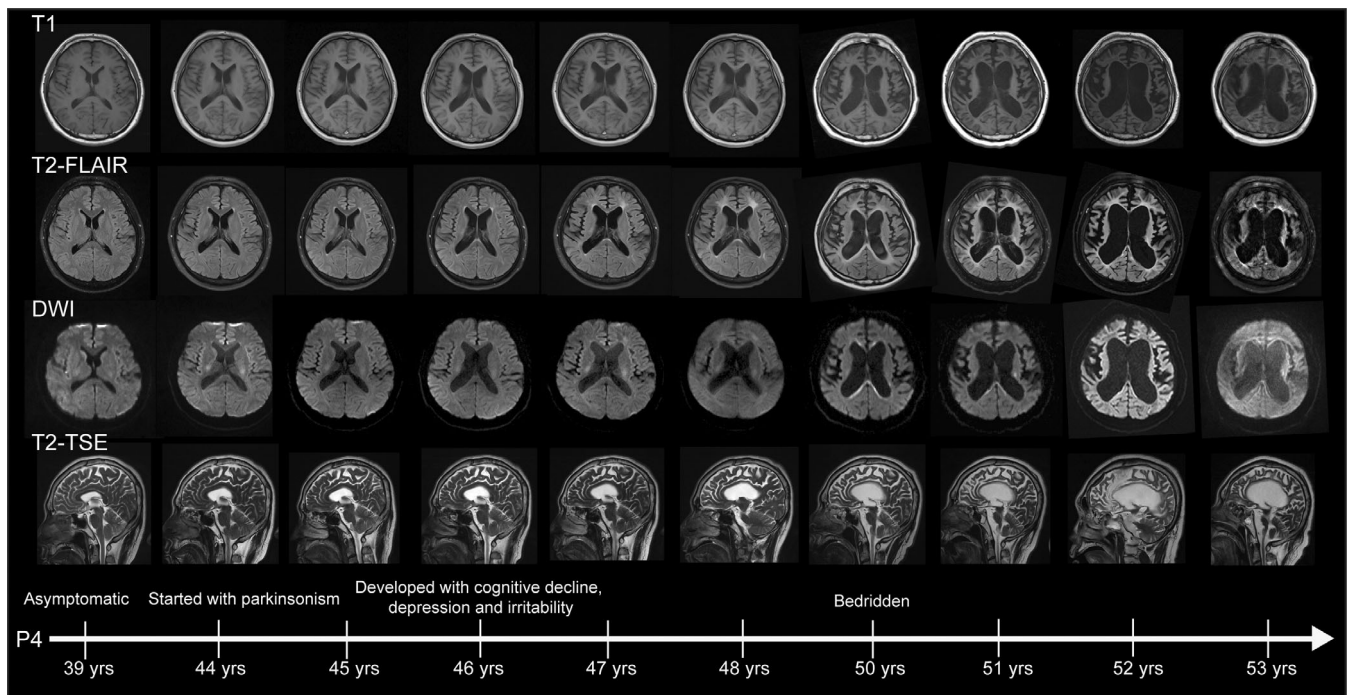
Dynamic follow-up of magnetic resonance imaging (MRI) of a male CRD (colony-stimulating factor 1 receptor-related disorder) patient (P4) carrying the c.2342C > A/p.A781E mutation from asymptomatic stage to bedridden stage. The patient developed clinical symptoms at the age of 44, manifesting as parkinsonism. Two years later, he developed cognitive impairment, and his personality and behavior changed, manifesting into anxiety and irritability. Six years after the onset of the disease, the patient was completely bedridden.
